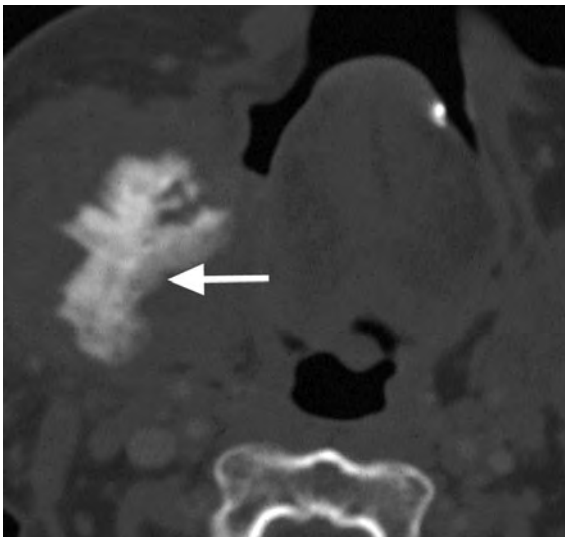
Intrinsic lesion of the right mandible in a 75-year-old male with numbness in the territory of the right inferior alveolar nerve territory caused by biopsy-proven chronic osteomyelitis. Axial CT image in bone-window-level-setting shows sunburst-like periosteal reaction (*arrows*) of the right mandibular ramus
